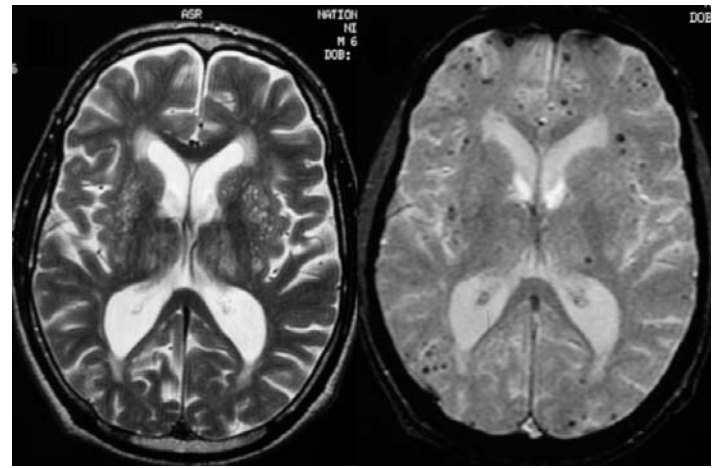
T2-weighted (a) and gradient-echo MRI (b) of a patient with frontal-executive dysfunction. Note the numerous microbleeds present, particularly in the frontal regions on the gradient-echo image (right hand panel), which are not visible on the T2-weighted image (left hand panel). The distribution is suggestive of cerebral amyloid angiopathy. Reproduced with permission from reference 33.
